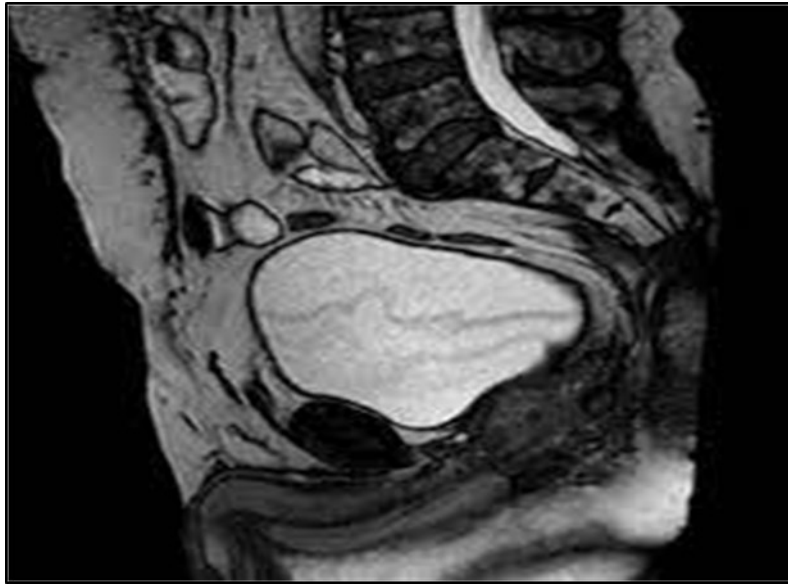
MRI of the same patient after catheterisation
